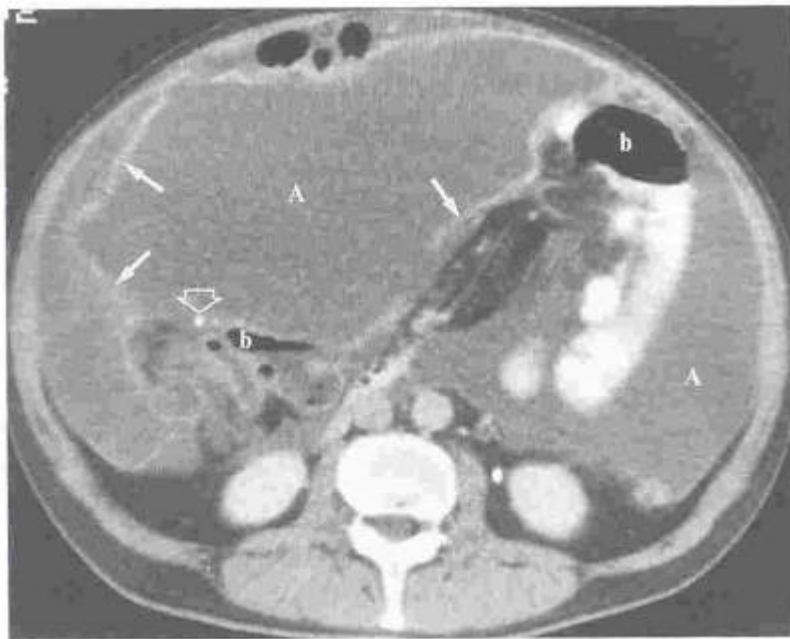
Pseudomyxoma Peritonei. A CT scan of a 65-year-old male with a ruptured appendiceal mucocele demonstrates copious ascites (*a*) with prominent septations (*closed arrows*) and mass effect displacing bowel loops (*b*). Punctate calcifications (*open arrow*) are also present on peritoneal surfaces.
